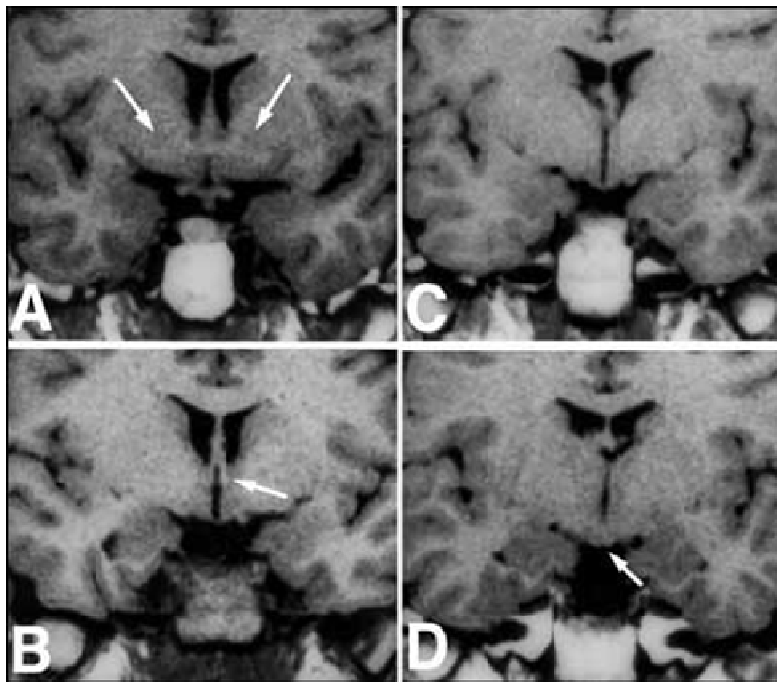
MRI of coronal sections through the hypothalamus. (A) Anterior hypothalamus corresponding to Fig. 10A showing location of the anterior commissure (arrows). (B) Mid hypothalamus corresponding to Fig. 10B showing location of the fornix (arrow). (C) Mid hypothalamus corresponding to Fig. 10C showing the optic tract. The fornix can sometimes also be visualized at this level. (D) Caudal hypothalamus corresponding to Fig. 10D at the level of the medial mammillary bodies (arrow). Sometimes the mammillothalamic tract can be visualized at this level.
